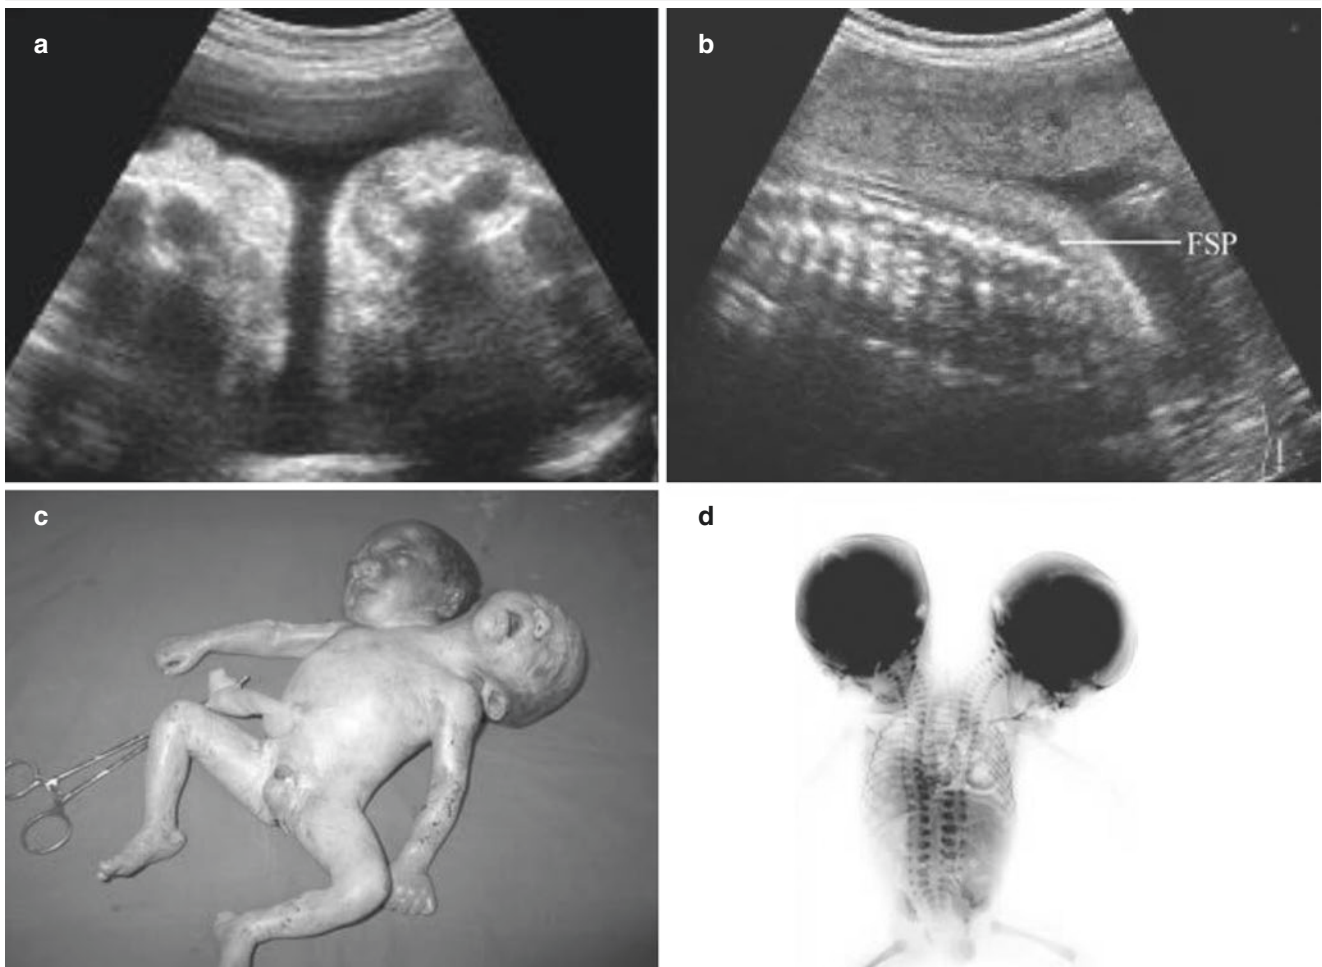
Conjoined twins IV. (a). Two separate fetal heads echo; (b). Two widened spines echo; (c). There are two heads and one body after induction of labor. (d). X-ray images of conjoined twins after labor induction
